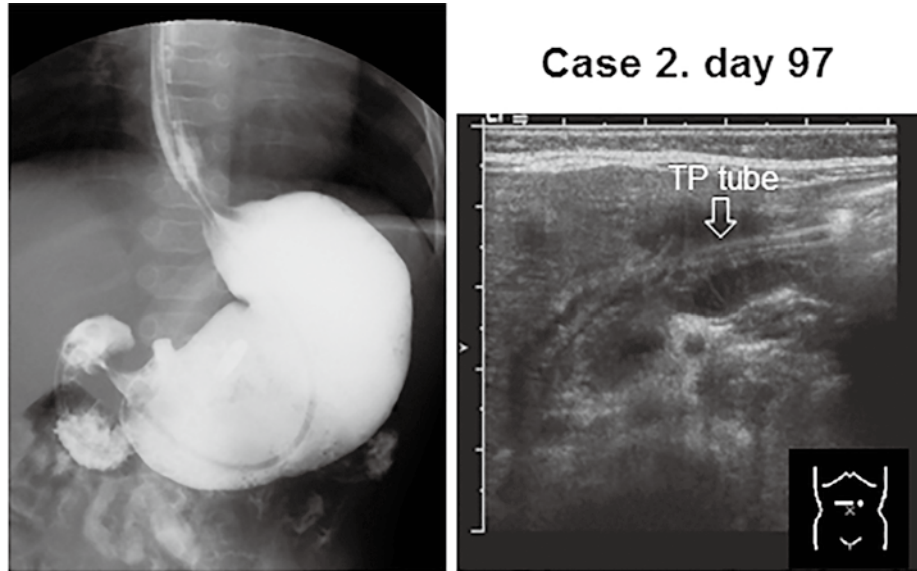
Upper gastrointestinal cineradiography showed gastroesophageal reflux and abnormal gastric emptying. Ultrasound showed a hypertrophied pylorus. The pyloric muscle thickness was 5.0 mm, and the canal length was 24 mm.
